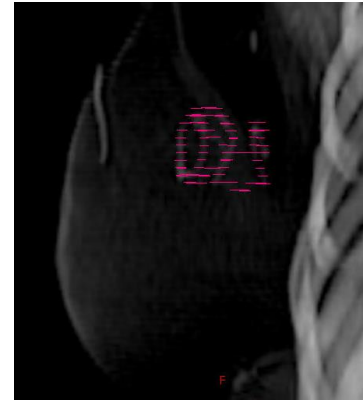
Pink Contour of FM overlaying the DRR: Gantry Rotation = 50°, Collimator Rotation = 0°, Couch Rotation = 0°, DRR parameters (Weight = 1, CT Window [HU] from 25 to 150).
